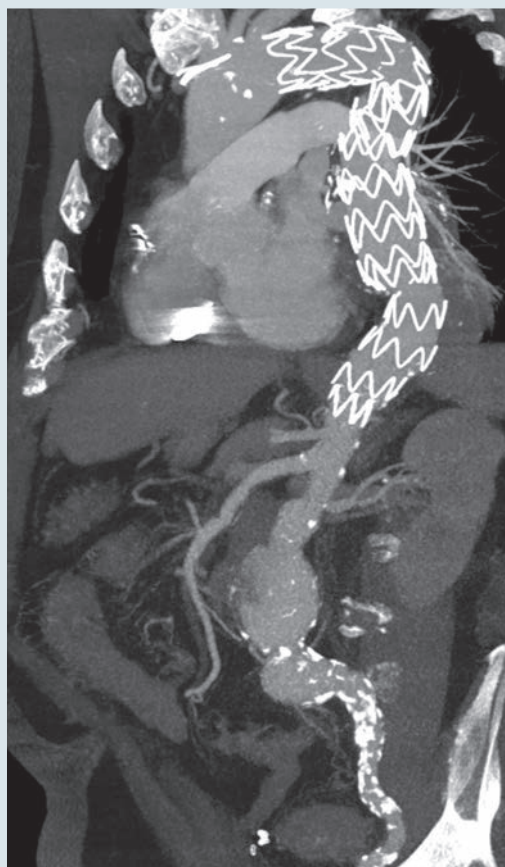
CT angiographic reconstruction showing the Zenith Alpha Thoracic device in a 72-year-old patient with aneurysmal disease of the thoracic, thoracoabdominal, and abdominal segments. Note the alignment of the stent graft with the tortuous aortic segments, as well as the presence of heavily calcified iliac arteries
